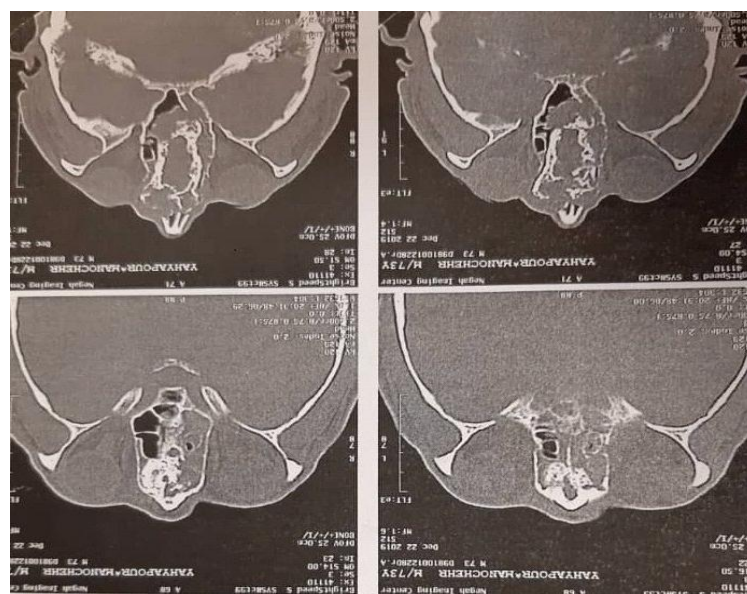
Chondrosarcoma CT-scan of ethmoidal sinus with axial cut
